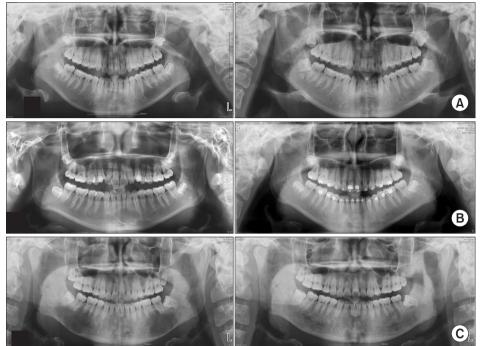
Radiographic changes six months postoperatively. All cases underwent surgical curettage of the lesion. A. Left: Initial lesion on the left posterior of the mandible. Right: Postoperative lesion. B. Left: Initial lesion on the anterior of the mandible. Right: Postoperative lesion. C. Left: Initial lesion on the right and left posterior mandible. Right: Postoperative lesion.
